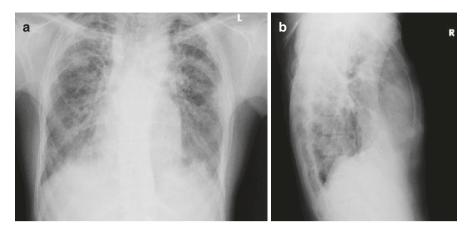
(a) Posteroanterior chest X-ray: bilateral dispersed regions of patchy shadows, pleural thickening in the upper pulmonary fields peripherally. (b) Lateral chest X-ray: chest shortening in the anteroposterior diameter—platythorax
